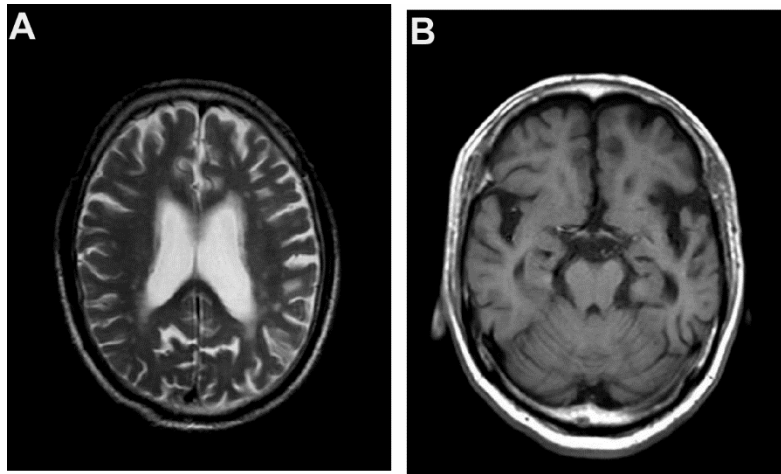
Structural magnetic resonance images of patient III:5 in family A. Axial T2-weighted MRI (A) and axial T1-weighted MRI (B) showed lacunar stroke and medial temporal lobe atrophy.
